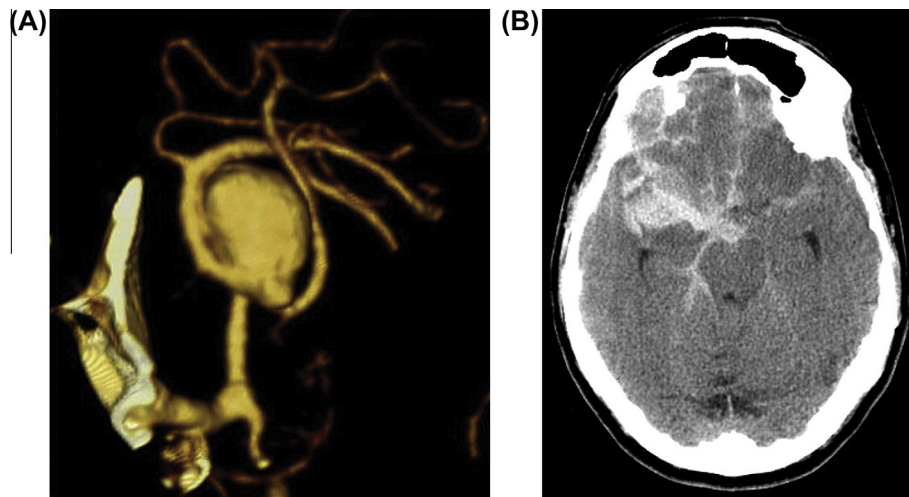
(A) Computed tomography angiography three-dimensional reconstruction demonstrates a right middle cerebral artery aneurysm responsible for (B) a Fisher grade III subarachnoid hemorrhage with a right Sylvian fissure clot seen on axial CT scan. Used with permission from Barrow Neurological Institute.
